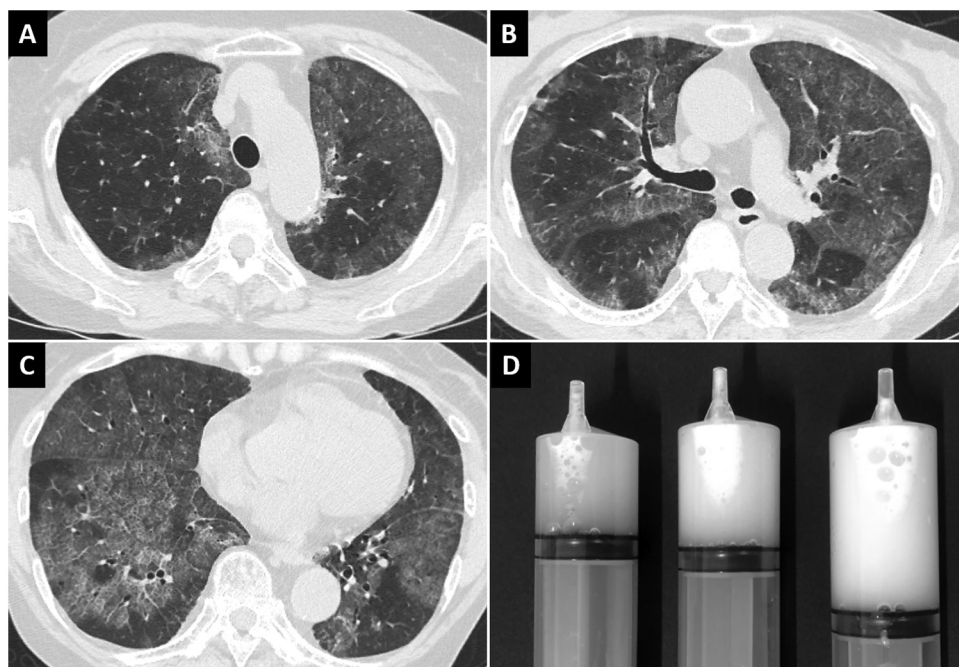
(A–C) Computed tomography image depicting diffuse ground-glass opacities in both lung fields. (D) Bronchoalveolar lavage fluid with a markedly cloudy appearance.
